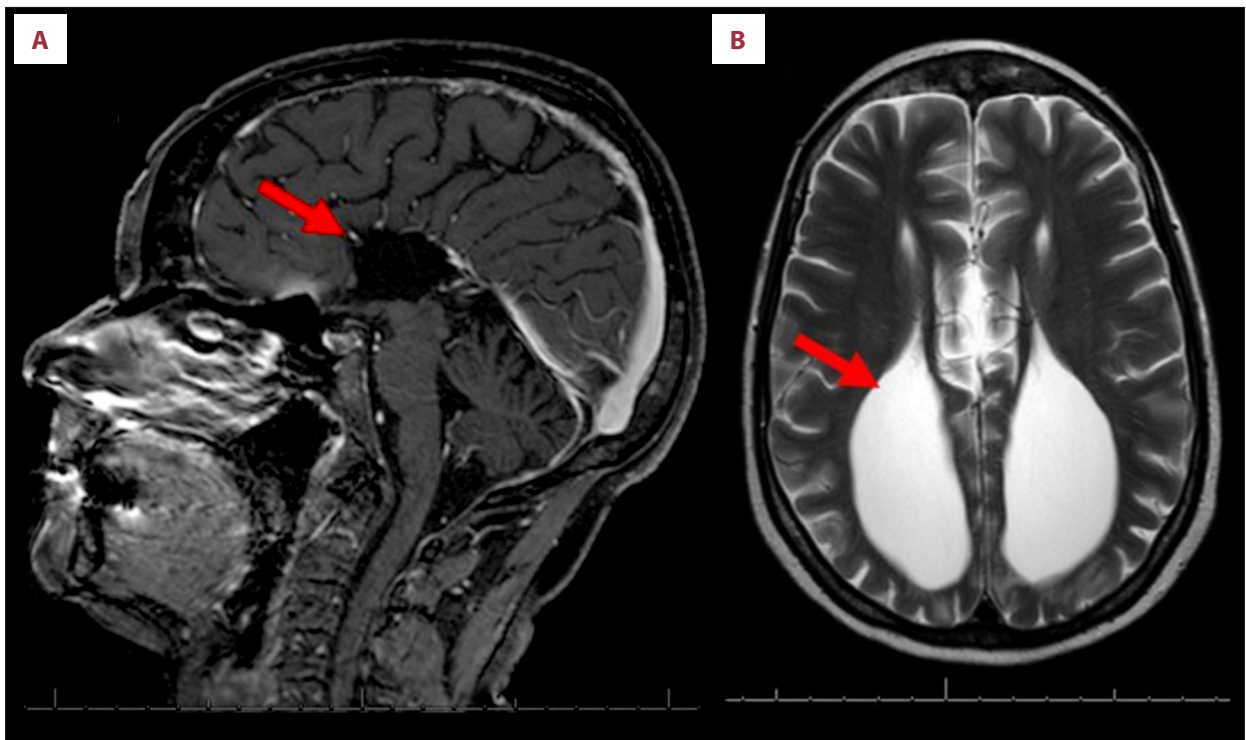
Magnetic resonance imaging (MRI) showing corpus callosum agenesis (CCA) in a 41-year old woman. (A) The absence of a corpus callosum (arrow) demonstrated on sagittal magnetic resonance imaging (MRI). (B) Hydrocephalus with colpocephaly (congenital enlargement of the posterior lateral ventricles or occipital horns, because the posterior cerebral white matter has failed to develop) (arrow) demonstrated on coronal MRI.
